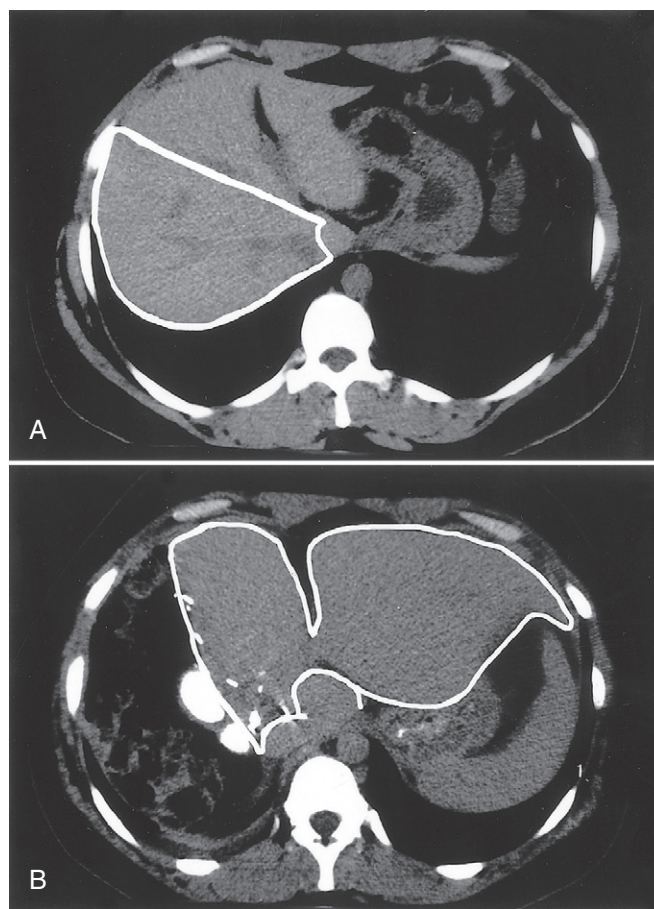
Regeneration of the liver. Computed tomography scans show a donor liver in living-donor liver transplantation. A, The donor liver before the operation. Note the right lobe (outline), which will be resected and used as a transplant. B, Scan of the same liver 1 week after resection of the right lobe; note the enlargement of the left lobe (outline) without regrowth of the right lobe.
